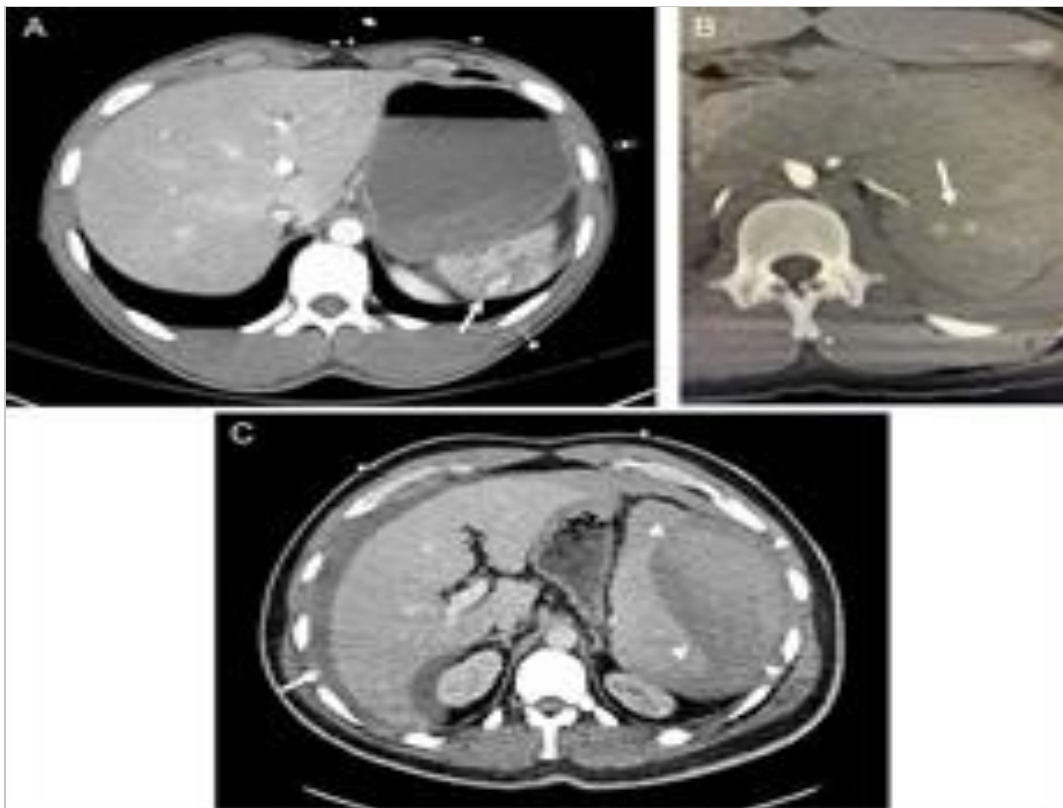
Computed tomography scan findings associated with increased risk of nonoperative management failure. (A) Active contrast extravasation. (B) Parenchymal pseudoaneurysm. (C) Large subcapsular hematoma (arrowheads) with moderate volume hemoperitoneum (arrow) (1).
